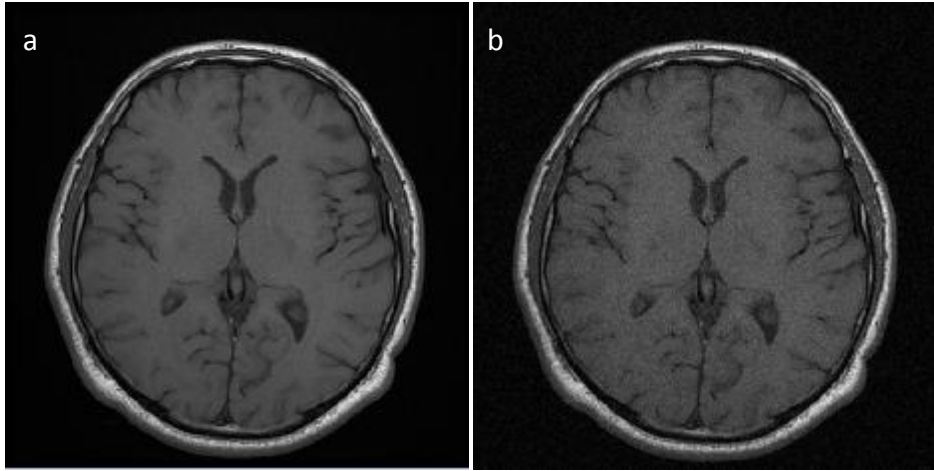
T1 weighted Axial MRI; a) Normal, b) Rician noise added images [12].
